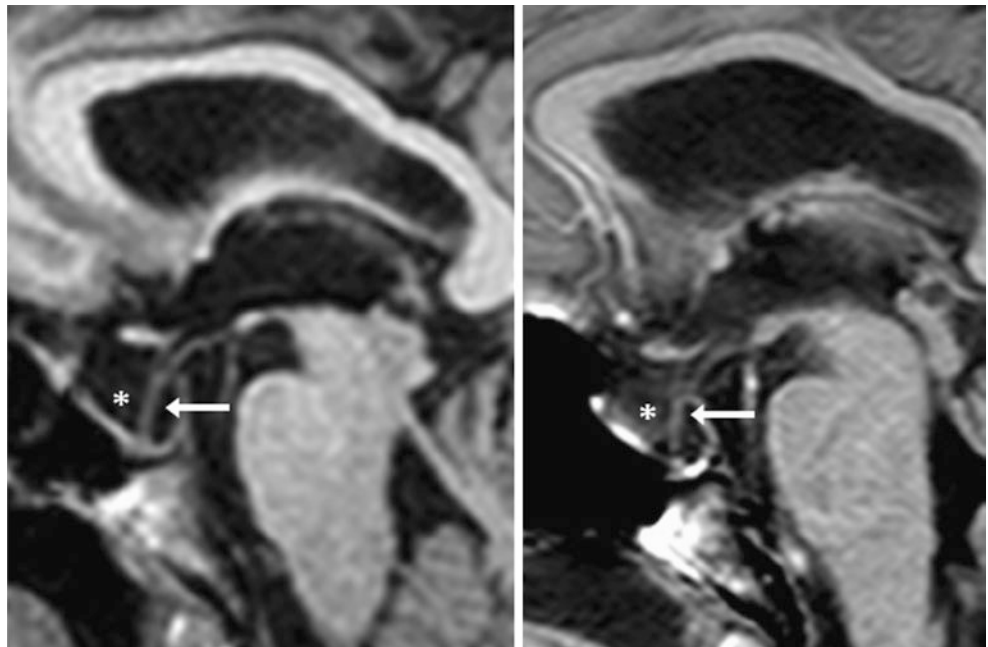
A 54-year-old patient with headaches. The stalk (*arrows*) of a PES (*) is not seen on noncontrast sagittal T1WI (*left*) but is found on axial FLAIR (*right*)
